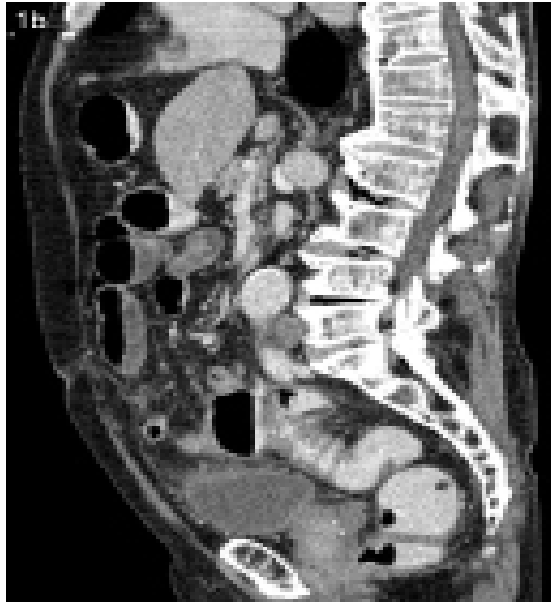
Computed tomography in sagittal view showing diffuse thickening of the rectosigmoid colon with fat streakiness
